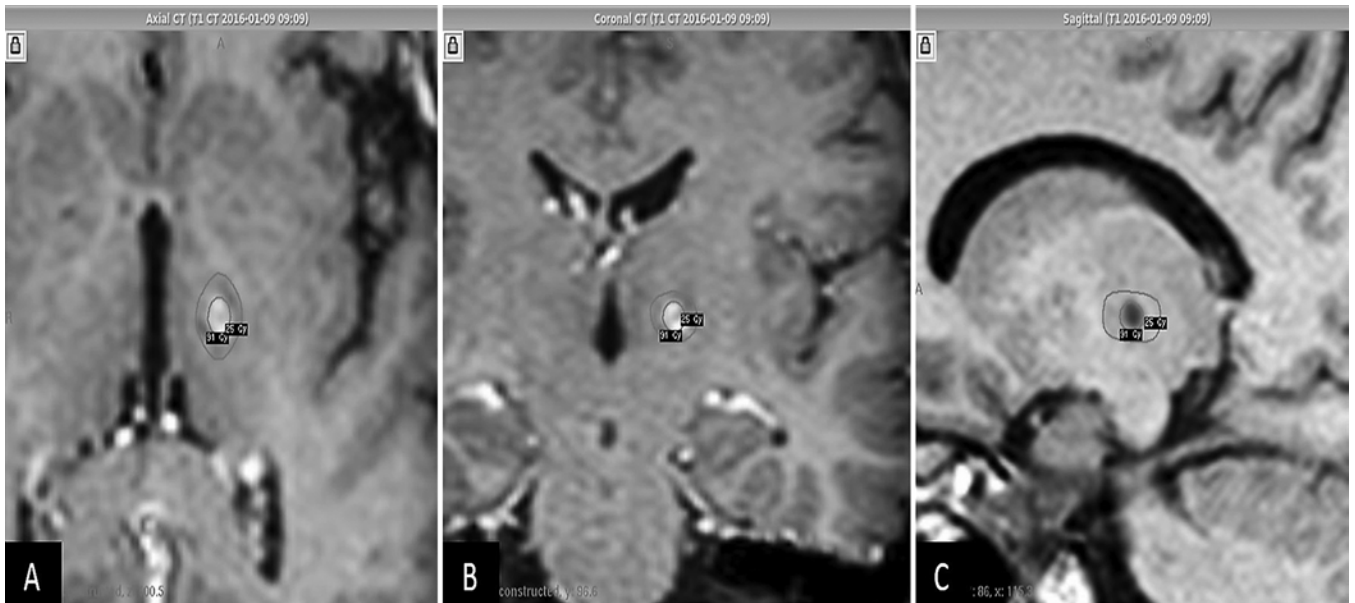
MR images showing changes 1 year after GKRS thalamotomy (maximum dose 130 Gy). A and B: Axial (A) and coronal (B) Gd-enhanced T1-weighted images showing a millimetric lesion measuring a few millimeters that correlates with the 91-Gy isodose line. C: Sagittal T1-weighted image showing a low-signal region that coincides with the 91-Gy isodose line.
